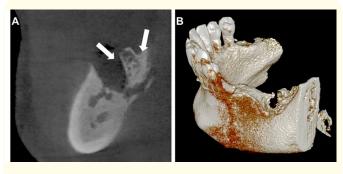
Cone-beam computed tomography images demonstrate extensive bone resorption and sequestration of osteoradionecrosis in the left mandibular molar region (white arrows). A) Sagittal view; B): Three-dimensionally reconstructed image showing the area of osteoradionecrosis.
